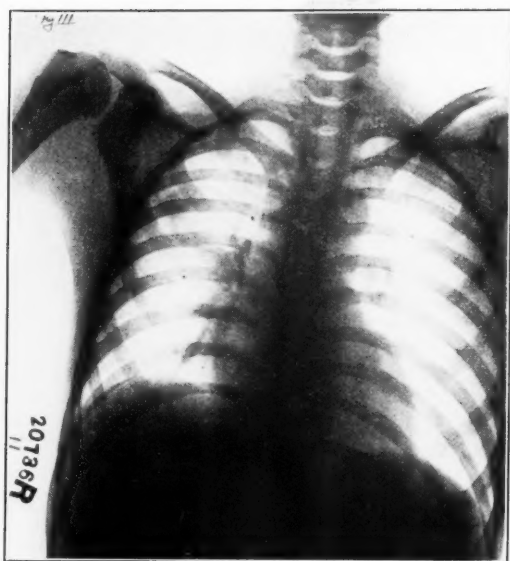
Roentgenogram of the same patient as Figs. 1 and 2, made two weeks after bronchoscopy showing the lung still clear, there being no return of atelectasis. This case has been reported in detail by Dr. Walter Estelle Lee in the proceedings of the annual meeting of the Pennsylvania Medical Society for 1927. Films by Dr. Thomas P. Loughery.
